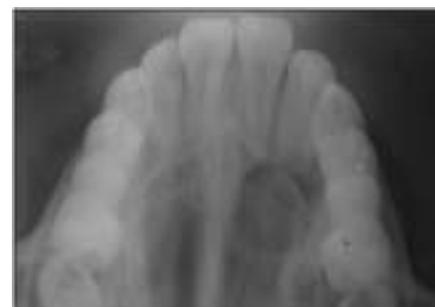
Pre Operative Occlusal Radiograph Showing Left Maxillary Lateral Incisor With Dense In Dente Type Iii Having Large Periapical Radiolucency And Open Apex.
